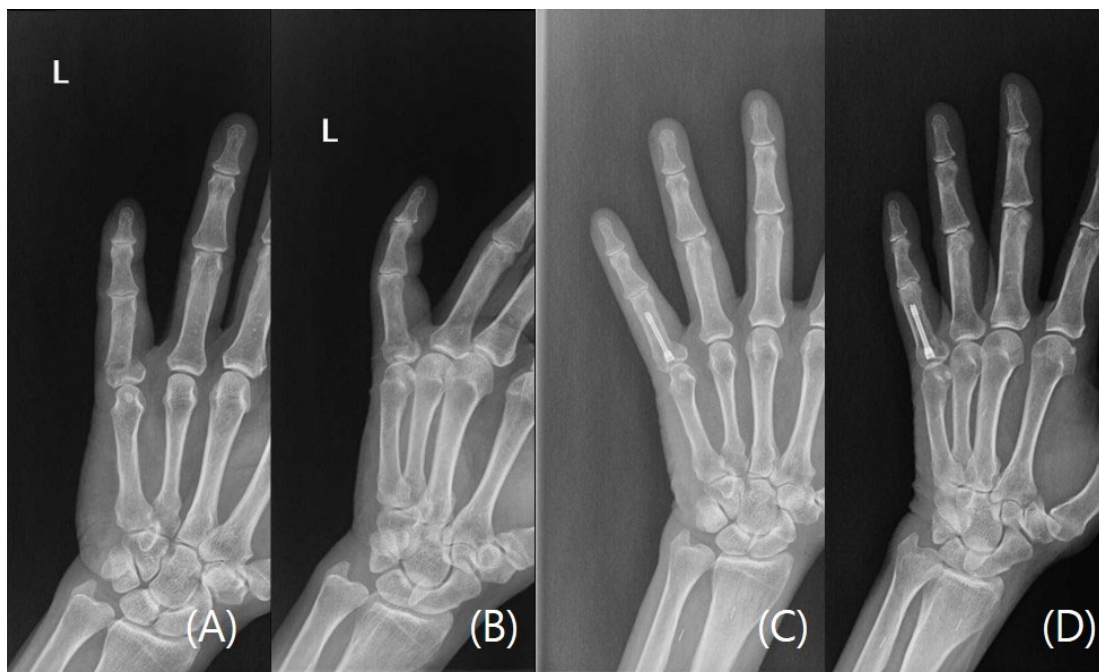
A case of a left fifth digit transverse proximal phalanx fracture. (a) Preoperative plain radiograph PA view; (b) Preoperative plain radiograph oblique view; (c) Postoperative plain radiograph PA view taken at last follow-up visit; (d) Postoperative plain radiograph oblique view taken at last follow-up visit.
